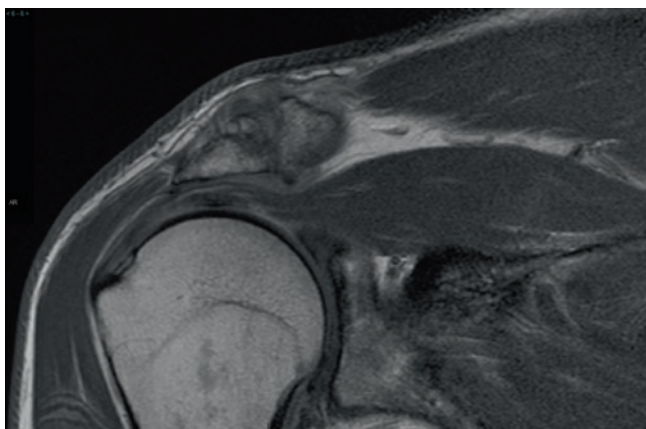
Coronal oblique T1-weighted image showing acromioclavicular joint degenerative changes with inferior osteophytes causing supraspinatus impingement
